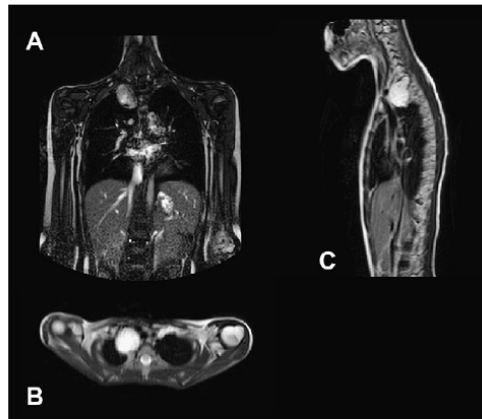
Magnetic resonance imaging of a voluminous paraganglioma in the upper mediastinum and upper aperture in a 13-year-old girl. (A) sB-TFE sequence in a coronal plane. (B) Transverse section (T₁-SER spin echo). (C) T₂ spin echo sequence in a sagittal plane. The paraganglioma (38 × 45 × 50 mm) of the right upper mediastinum and upper aperture at the level of C7/Th1–Th4/5 propagates to the right foramen intervertebrale Th1/2 and dislocates adjacent large vessels. The expansion presses the trachea medially and propagates into the dilated right foramen intervertebrale Th1/2, touching the dural sac without compressing it.
